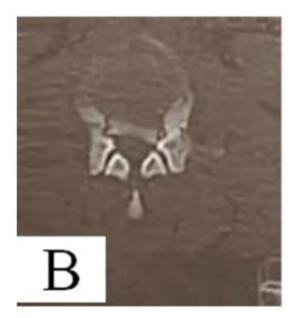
Pre-operative CT Lumbosacral spine showing L1 burst fracture. (A): Sagittal cut. (B): Axial cut.
